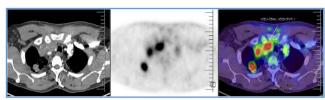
Axial CT, PET and PET/CT Fused Images showing FDG Avid Lymph Nodes in the Upper Paratracheal Region (2R Mediastinal Station)
